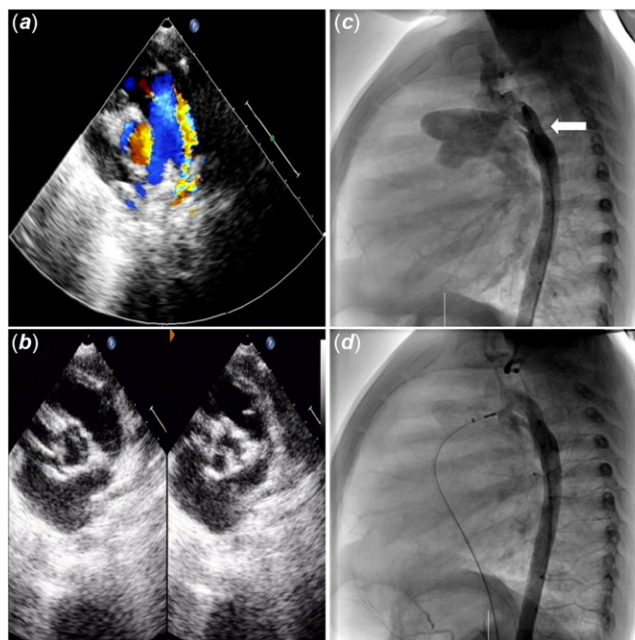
Perioperative images. Outpatient echocardiography showed patent ductus arteriosus (A) and bicuspid aortic valve (B). Pre- (C) and post-procedural (D) aortography. White arrow indicated aortic dysplasia.
